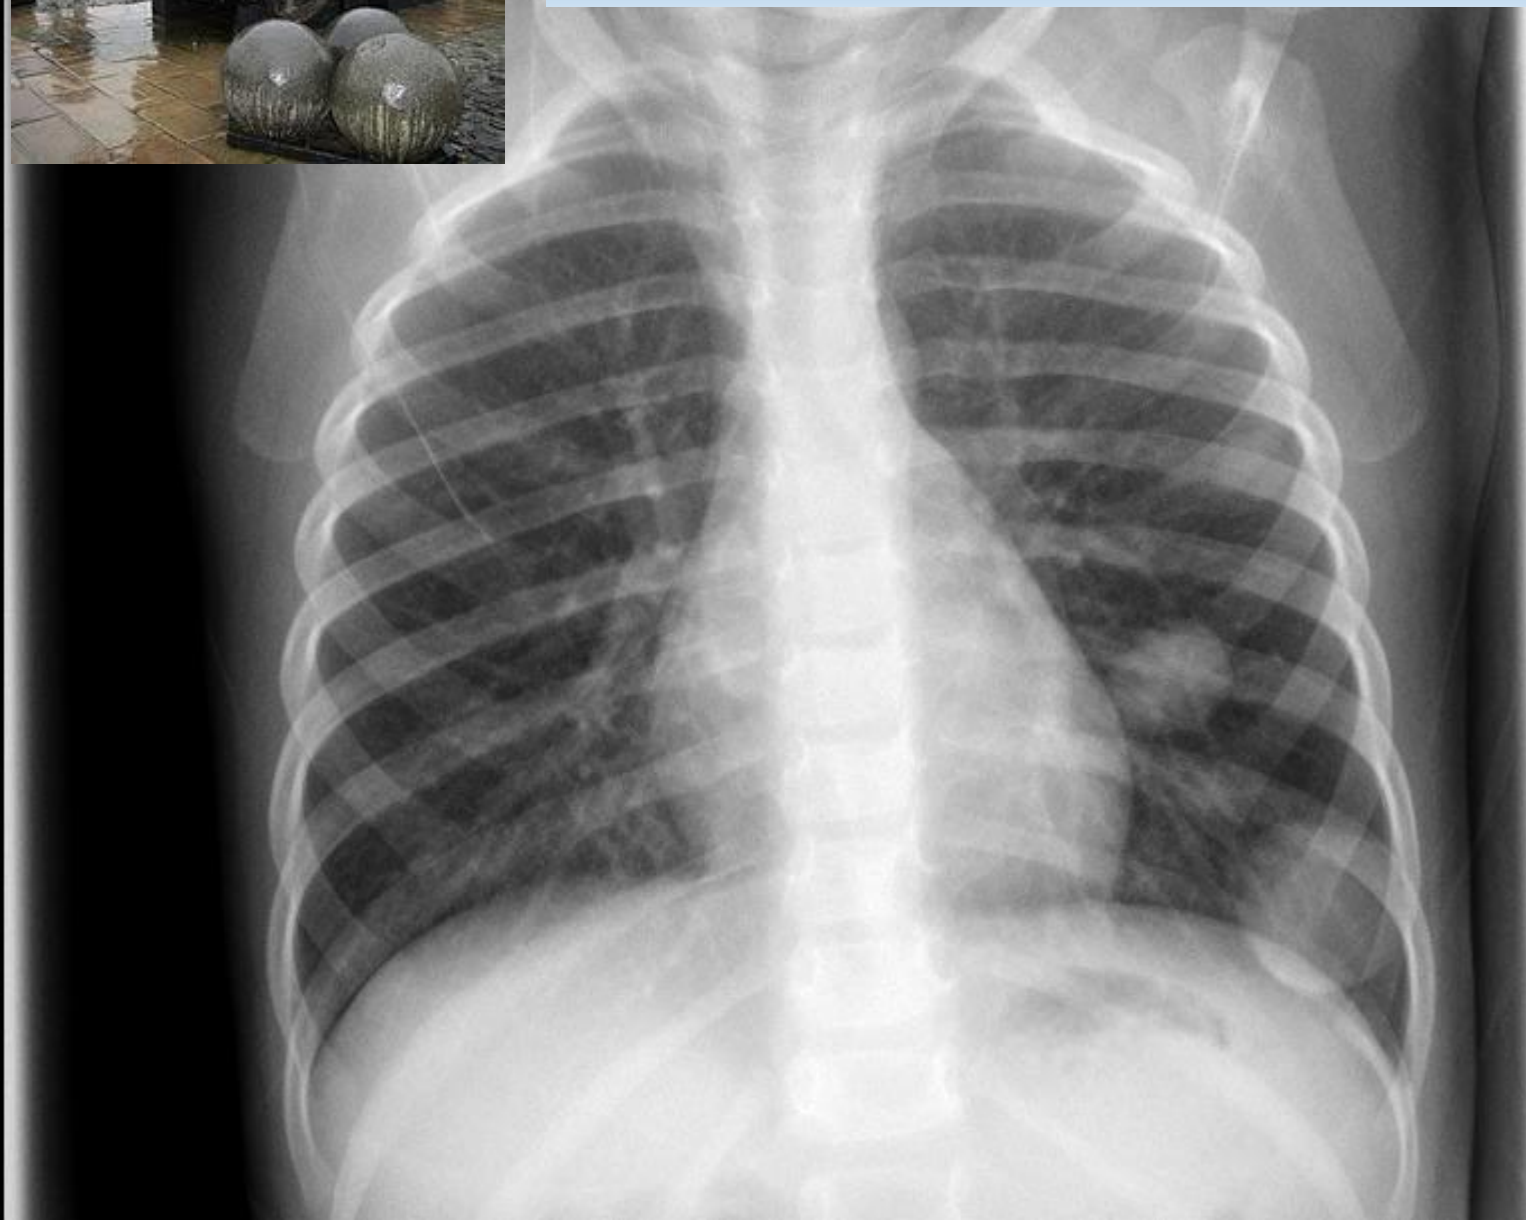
Uncomplicated hydatid cyst. A: Posteroanterior view of chest X-ray showing well defined round radio-opacity in right lower zone; B: Chest X-ray showing multiple well defined round opacities in left lung. Also note presence of calcified cyst in liver (arrow in B), which makes diagnosis of hydatid cyst almost certain.
